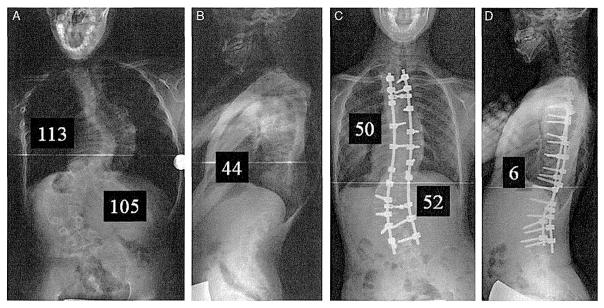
Radiographical findings of Patient 3. A double curve pattern with Cobb angles of 113 and 105 degrees (A) and local kyphosis of 44 degrees at the thoracolumbar junction are shown (B). Postoperatively, the main curves were corrected to Cobb angles of 50 and 52 degrees (C), and the kyphosis was corrected to 6 degrees (D).
